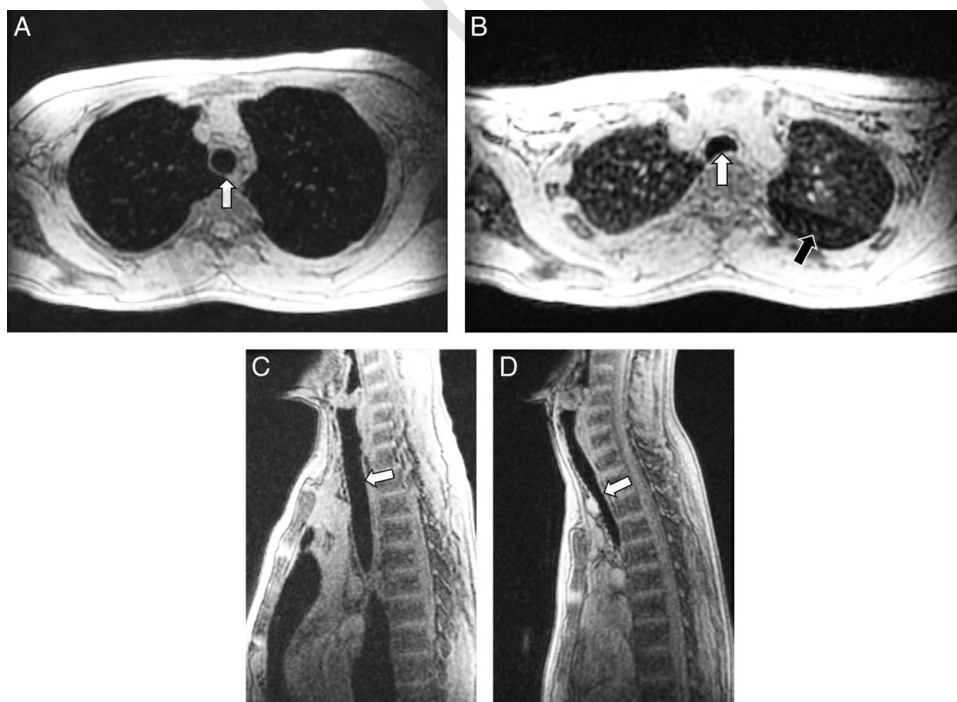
A 16-year-old boy with tracheomalacia. A, Axial nonenhanced PD-weighted spirometer-controlled MR image obtained at end-inspiration shows normal caliber trachea (arrow). B, Axial nonenhanced PD-weighted spirometer-controlled MR image obtained at end-expiration shows partial tracheal collapse (white arrow) and air trapping (black arrow) in the superior segment of the left lower lobe. C, Sagittal nonenhanced PD-weighted spirometer-controlled MR image obtained at end-inspiration shows normal caliber trachea (arrow). D, Sagittal nonenhanced PD-weighted spirometer-controlled MR image obtained at end-expiration shows partial tracheal collapse (arrow).
